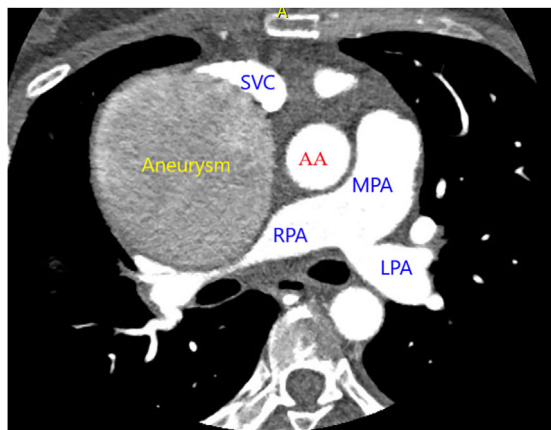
Computed tomographic chest scan showing large coronary artery aneurysm with extrinsic compression of RPA. AA, ascending aorta; LPA, left pulmonary artery; MPA, main pulmonary artery; RPA, right pulmonary artery; SVC, superior vena cava
